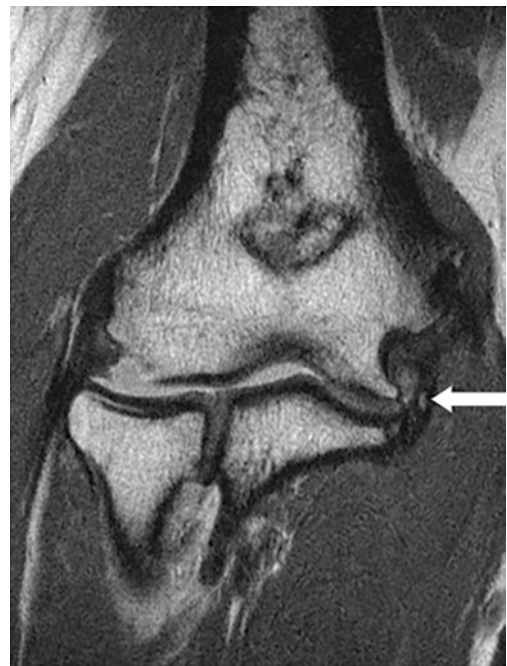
Coronal FSE MR image demonstrates a focus of intraligamentous ossification in a chronically injured UCL (*arrow*)
